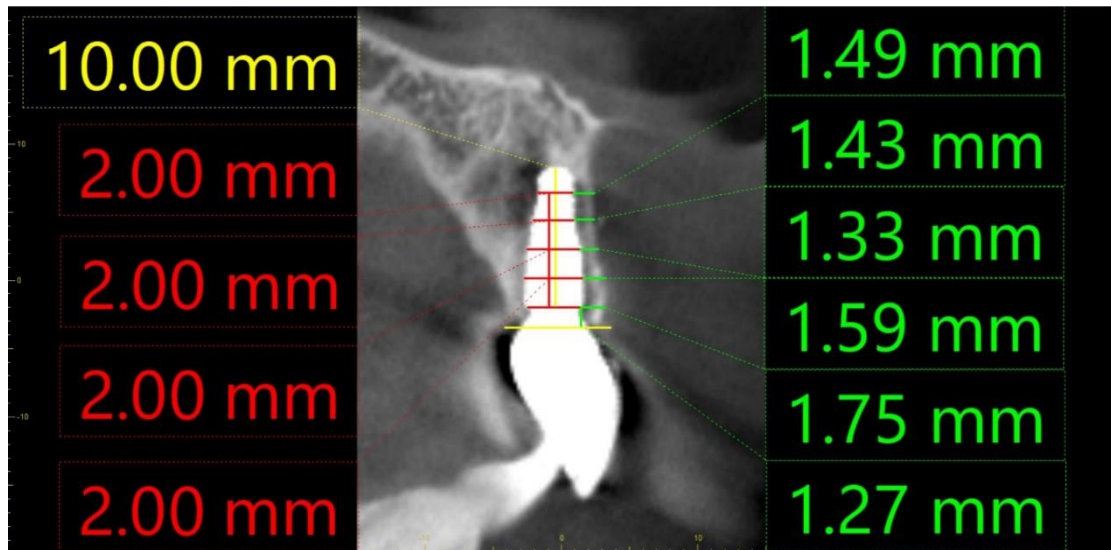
shows radiographic image in sagittal view shows vertical facial bone height and horizontal facial bone height at 0, 2, 4, 6, and 8 mm.
